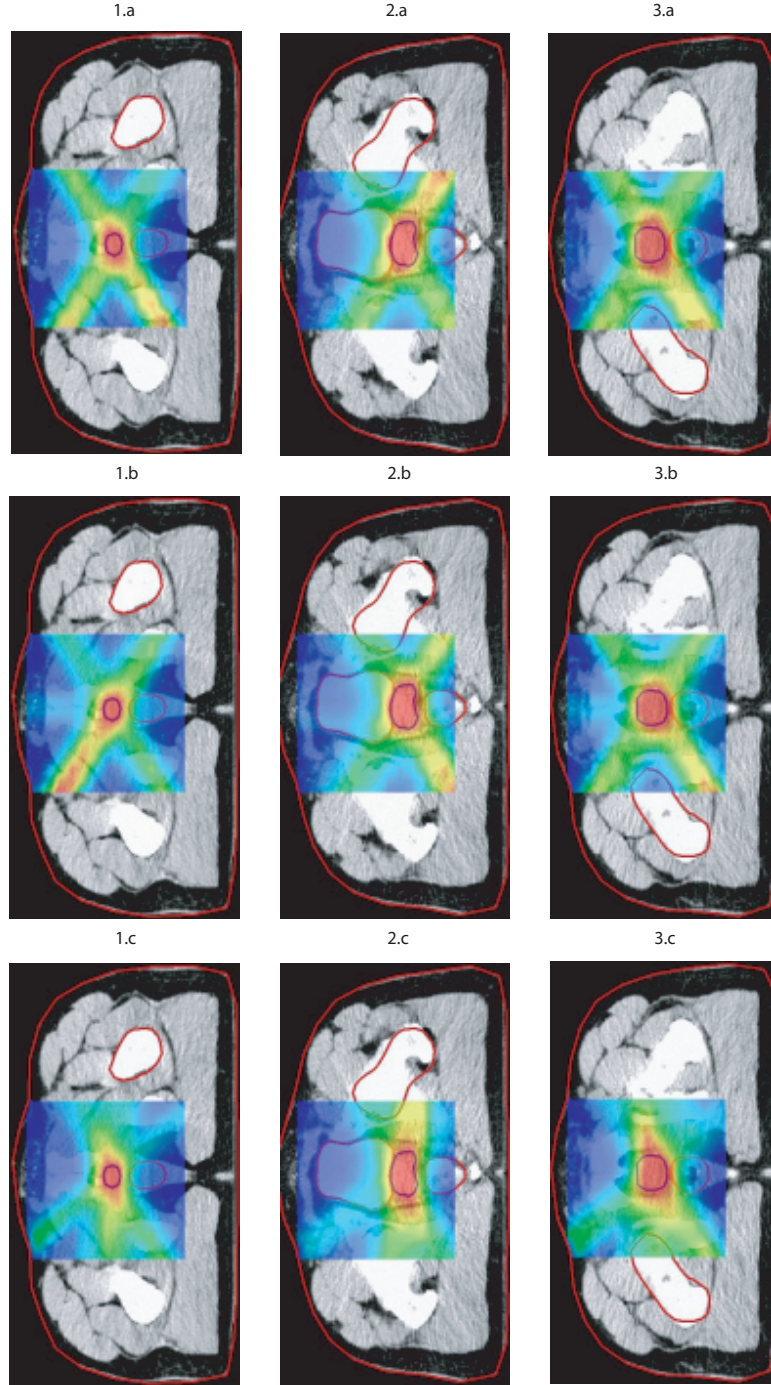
Prostate Case Dose Distribution: (a) Basic 6 Equi-spaced Beams Solution, (b) Final 6 Equi-Spaced Beams Solution, (c) Final 6 Selected Beams Solution are shown with a colorwash dose distribution overlaid with three CT axial images. The prescription dose is shown as red colorwash with 75, 50 and 25% of prescription dose shown as yellow, green and blue colorwash, respectively. CT axial images 1, 2, and 3 represent inferior, mid and superior slices through the prostate shown as a blue contour. The red contours on slice 2 show the bladder and rectum structures.
